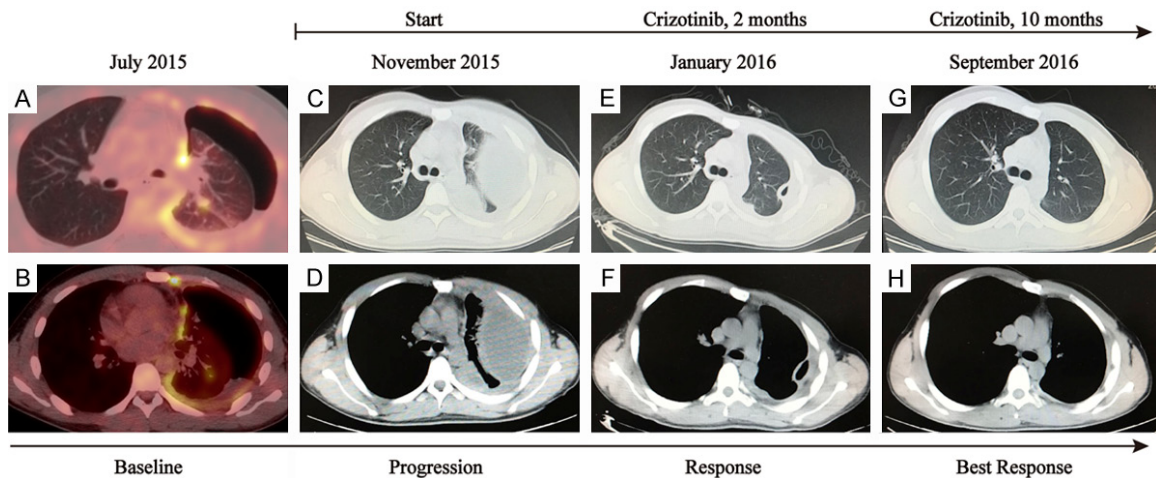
A-H. Radiographic evidence of clinical response to crizotinib. After having undergone two systemic treatments, in November 2015 patient started crizotinib treatment, which led to deep and prolonged response upon diffuse pleural metastatic sites.
